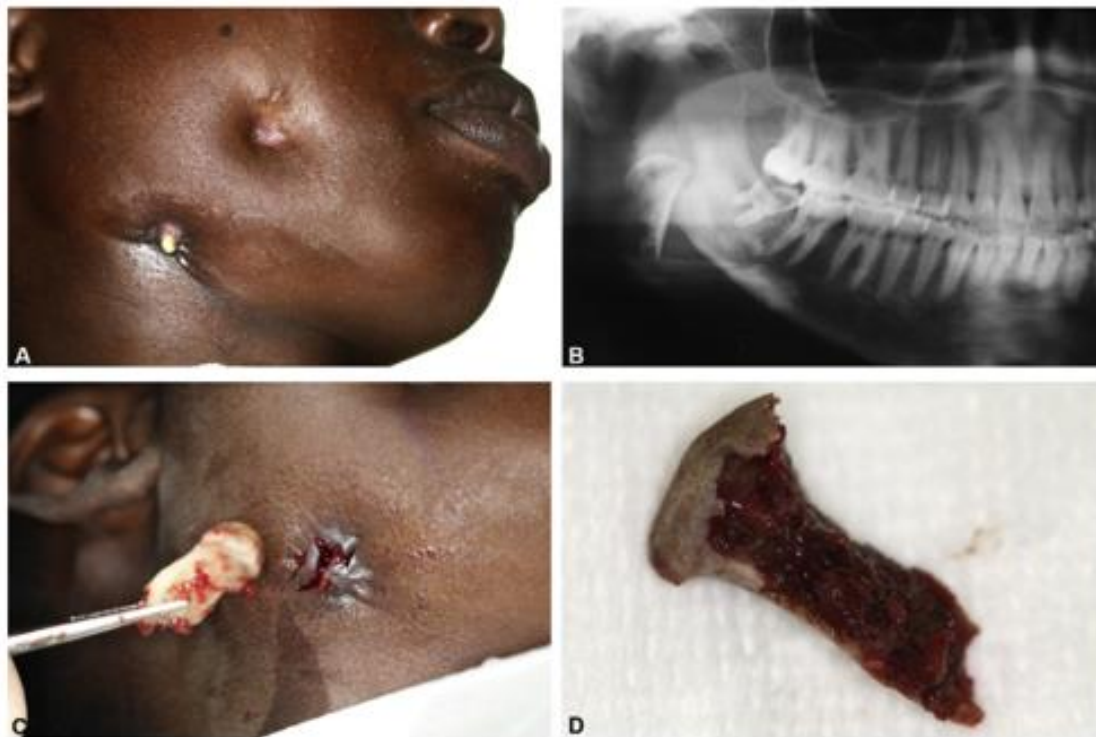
A female, 22 years, with right-sided swelling with draining extraoral fistulae (A). Right condylar head with a "floating" appearance on the panoramic radiograph, and a decayed lower third molar (B). The condylar head was extracted through the fistula (C), and exhibited severe osteonecrosis medially.<sup>1</sup>
